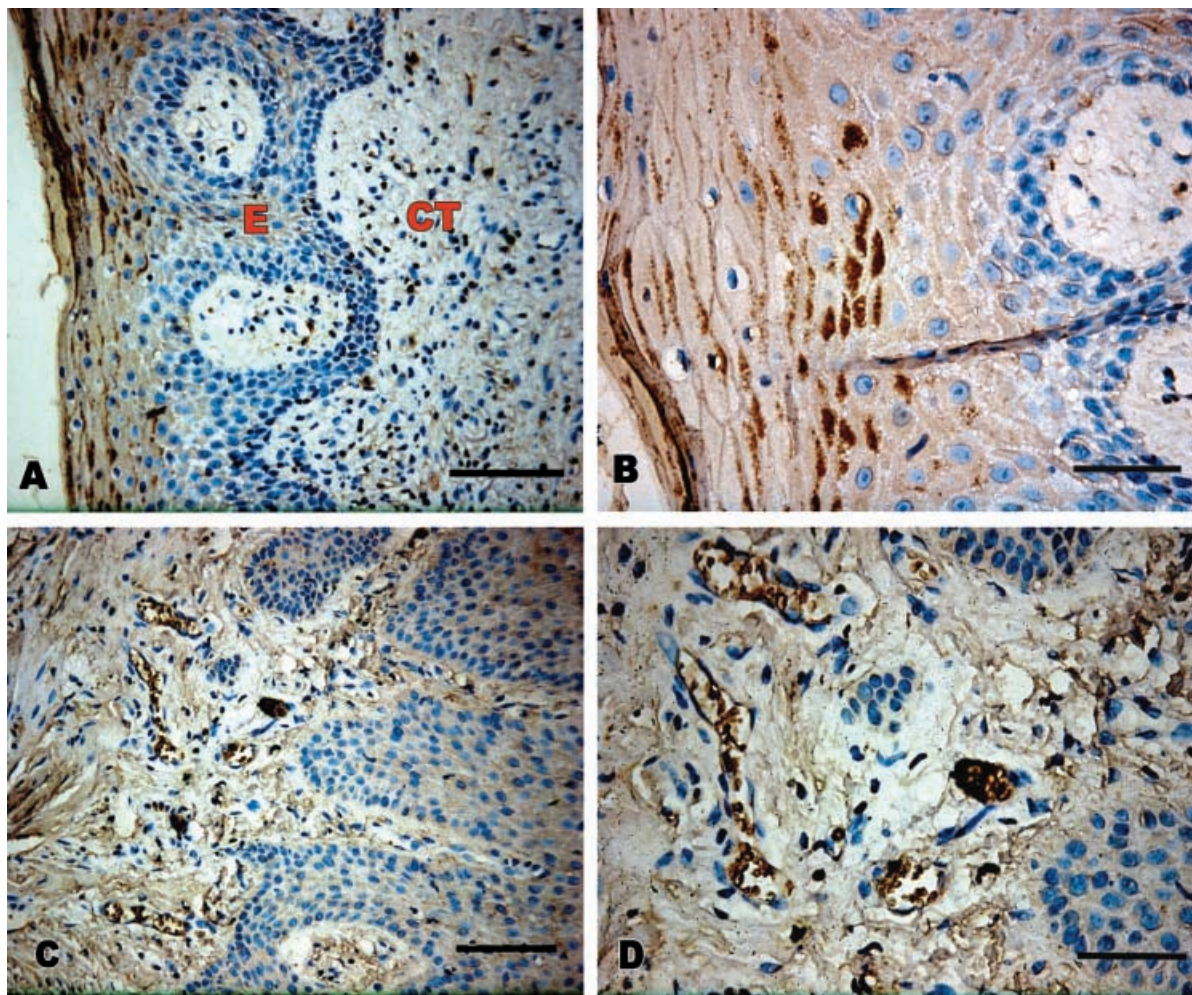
(A) Significant expression of lipopolysaccharide-binding protein (LBP) in the gingival biopsies of subjects with chronic periodontitis. E: epithelium; CT: connective tissue. (B) Expression in cytoplasm of granular and keratinized layers. (C and D) Expression at the blood vessels of subepithelial connective tissue. Bars = 100 μ m (A and C); bars = 50 μ m (B and D).
